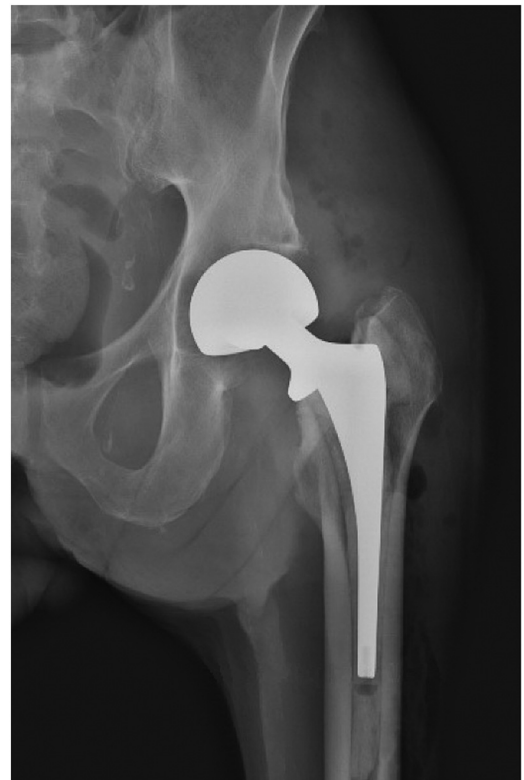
Postoperative radiograph of the left hip. Immediate postoperative anteroposterior radiograph of the left hip demonstrating a cemented bipolar prosthesis.
